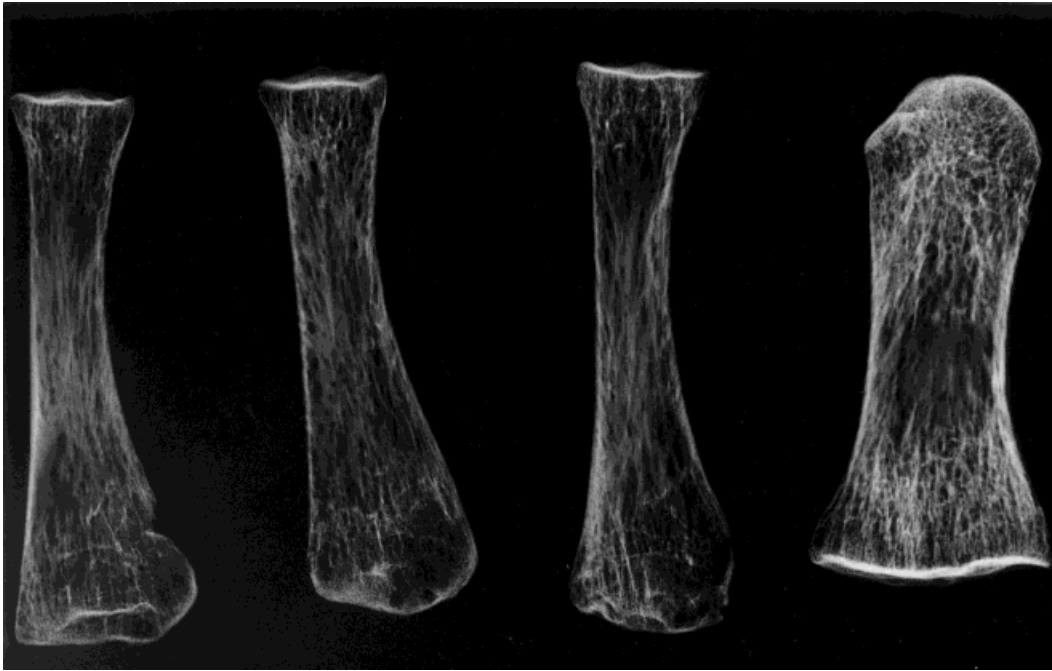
Anterior posterior x-ray of metatarsals (HTH 1115). Generalized osteopenia with focal linear resorption.
